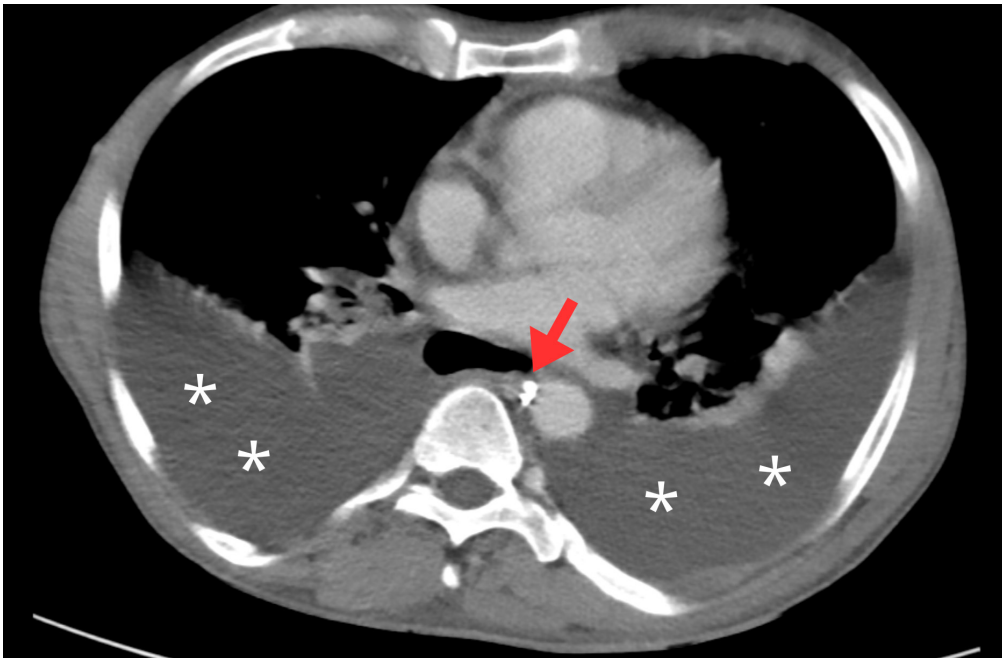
Native CT scan of the trunk performed the day after lymphangiography showing no Lipiodol leakage outside the lymphatic system.
